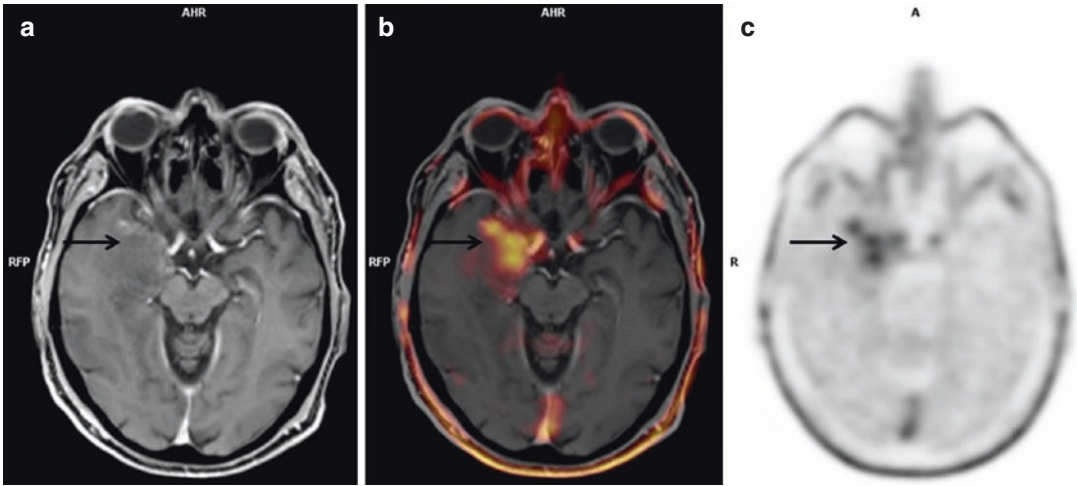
Axial MRI (a), fused ^{18}F -FET PET/MRI (b) and ^{18}F -FET PET (c) images in a 54 y.o. female patient with a suspicious right temporal glioma (arrows). ^{18}F -FET PET shows an area of increased radiopharmaceutical uptake
